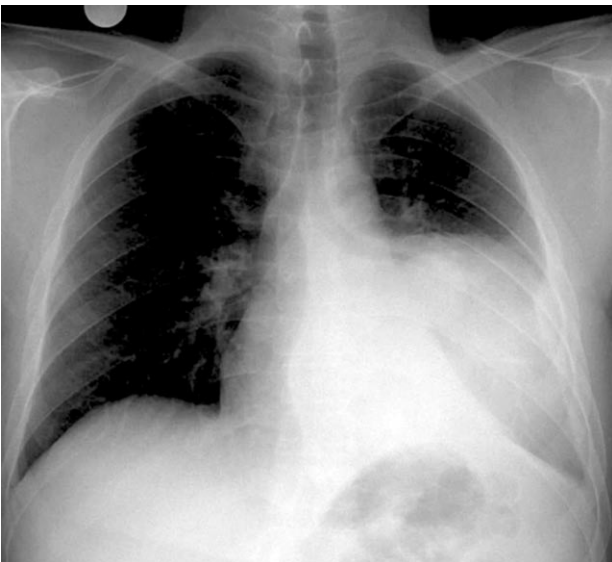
Chest radiography showing a large lobulated mass in the left lower zone. Calcifications are not seen in this radiography.
